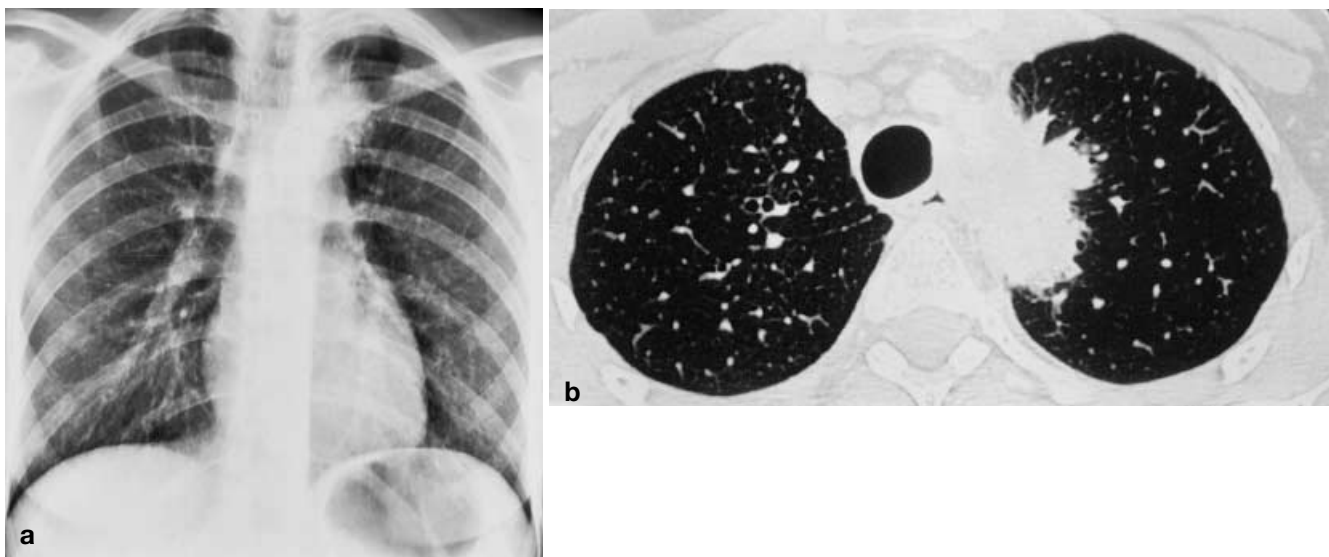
A 36-year-old female (patient 30) with recurrent nodular sclerosing HD and clinical diagnosis of pulmonary involvement. a Chest radiograph. b High-resolution CT scan at level of aortic arch: lung manifestation by direct extension from left upper mediastinal mass
